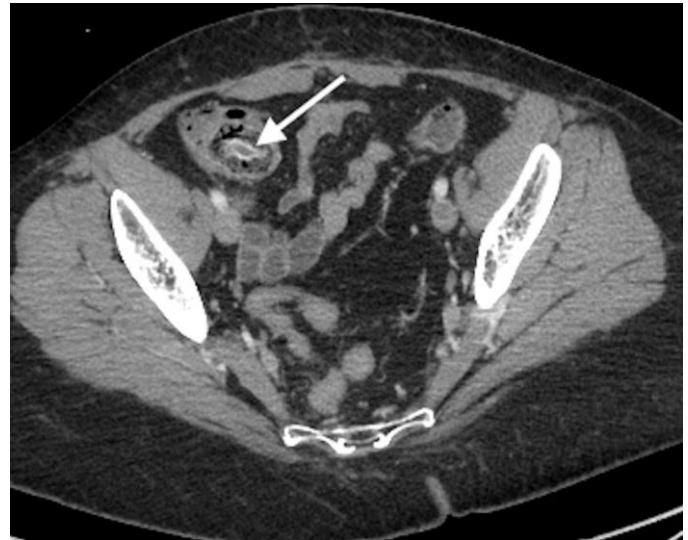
54-year-old female with appendiceal intussusception. Findings: Axial contrast-enhanced CT of the pelvis demonstrates an 8 mm, "targetoid" lesion within the cecum with strong mucosal enhancement. Technique: Axial CT, 419 mAs, 120kV, 2 mm slice thickness, 100 mL Isovue 300.
